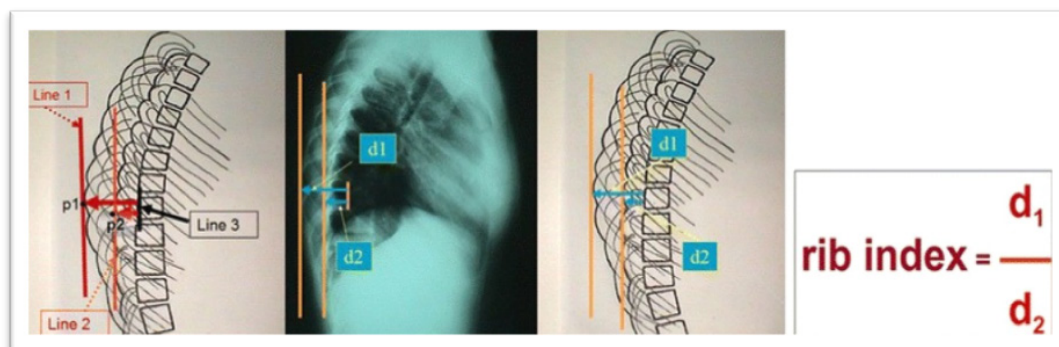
The way the RI is assessed on the standing lateral spinal radiographs.<sup>64</sup>
